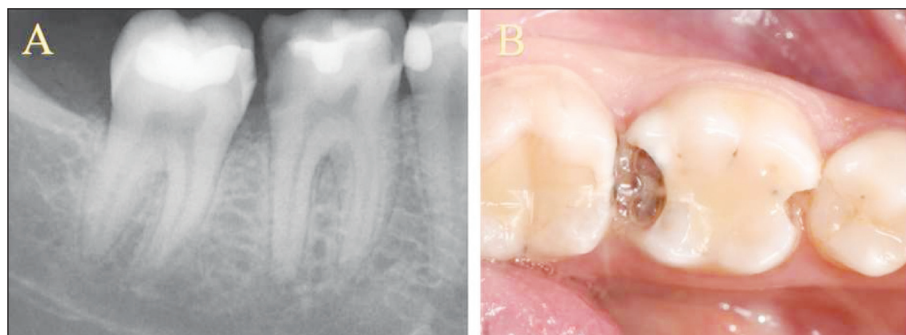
Initial radiography (A) and photograph (B)
